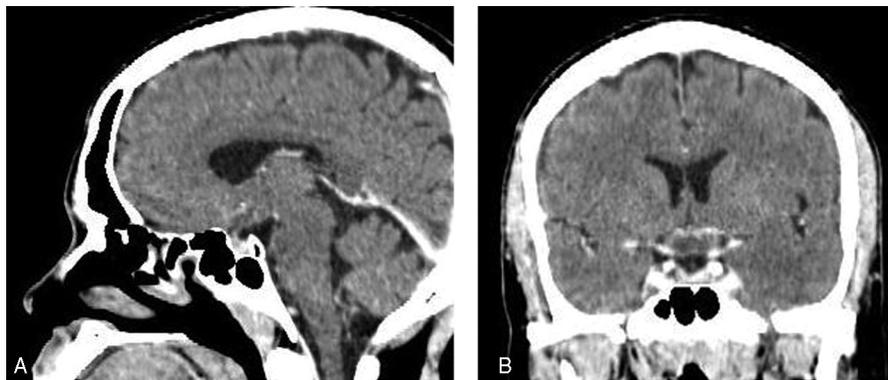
Cranial CT scan with contrast (a) sagittal view; (b) coronal view showing a sellar mass with suprasellar extension
